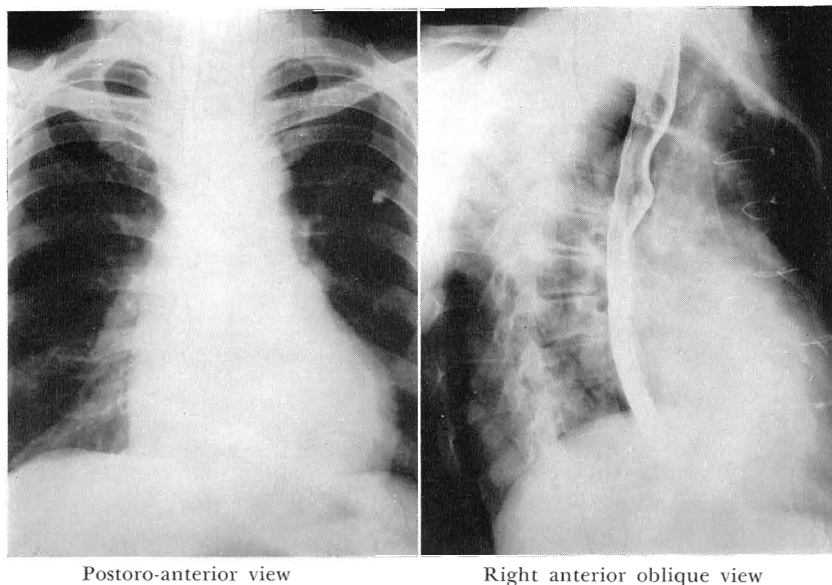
Postoperative roentgenogram of the chest. Note the diminution in the size of the right heart.
